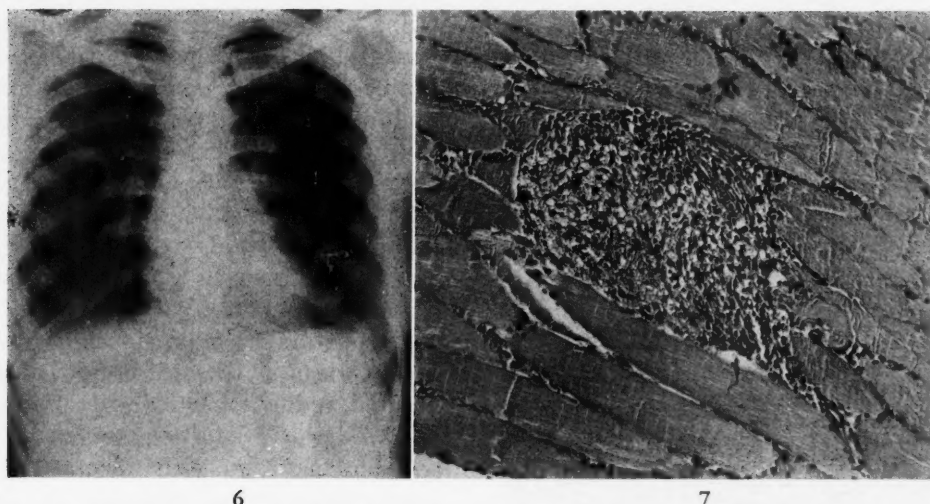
Case III. X-ray of chest showing enlarged hilar lymph nodes and diffuse reticulations throughout both lung fields.
